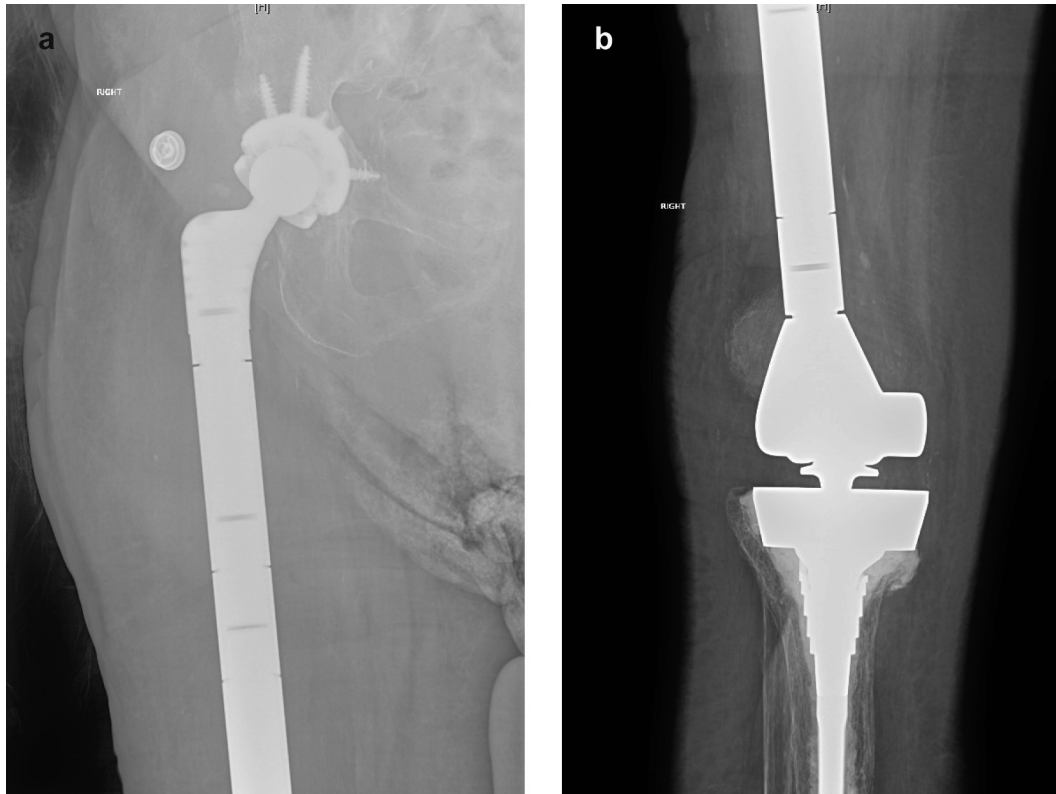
Postoperative AP femur (a) and knee (b) radiographs of total femur arthroplasty following second-stage reimplantation surgery for patient 1. AP, anteroposterior.
